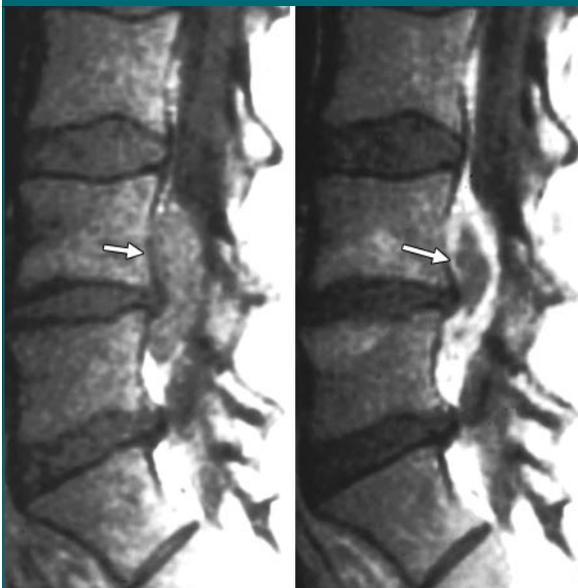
Extruded disk and free fragment. Sagittal T1-weighted SE (450/17) before (left) and after (right) contrast enhancement through lower lumbar spine. Note large extruded L4-5 disk fragment that has migrated superiorly behind the body of L4 (arrow). After administration of paramagnetic contrast media, there is peripheral enhancement of this mass, which represents granulation tissue within the epidural fibrosis surrounding nonenhancing central core of disk material.
